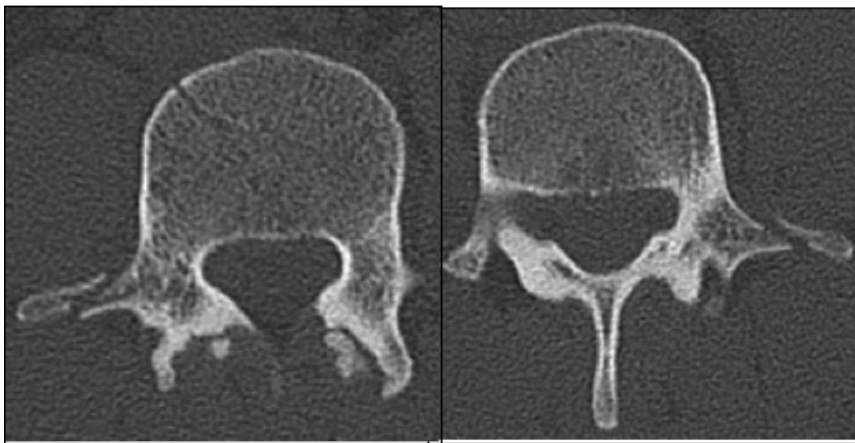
CT scan showing a transverse process fracture of L4.
